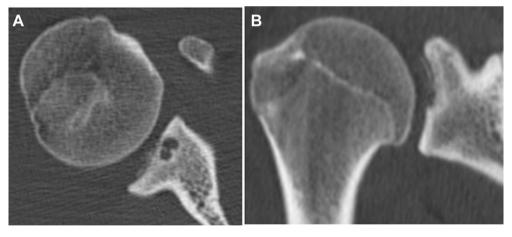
Computed tomography 4 months after the first visit (A, B) showed no change in the lesion.
